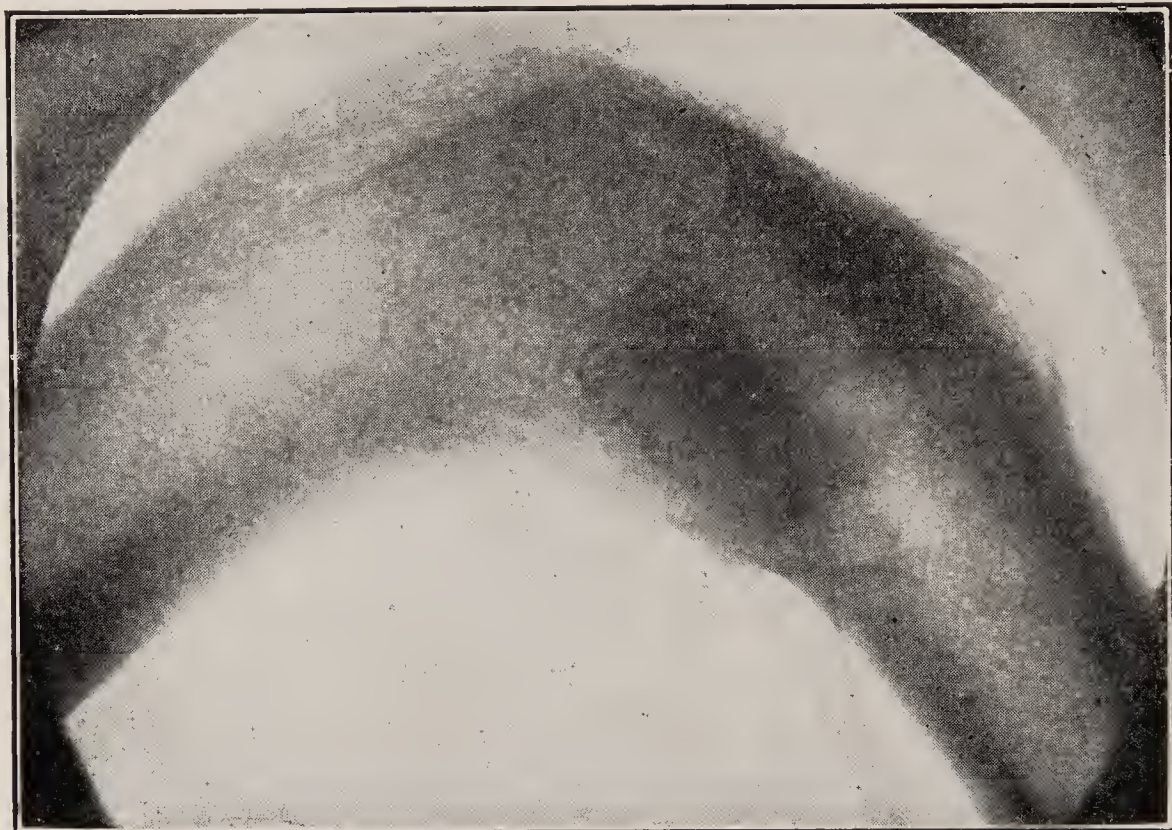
X-ray of bony ankylosis in knee joint.
